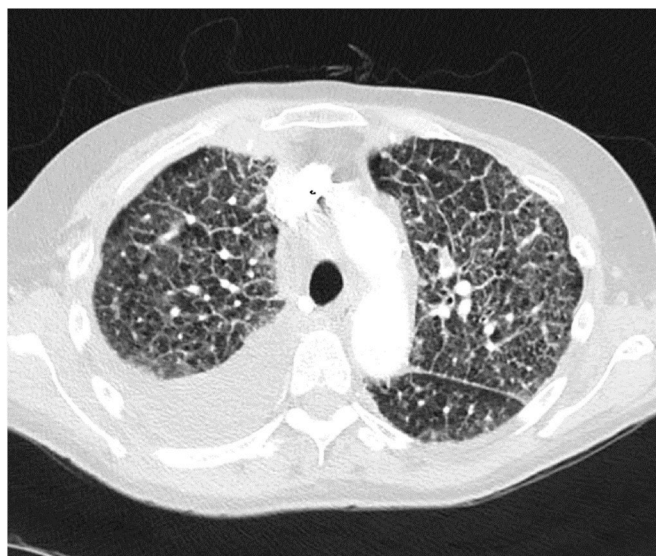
CT chest demonstrating bilateral diffuse interstitial opacity and interlobular septal thickening along with the right side pleural effusion.
